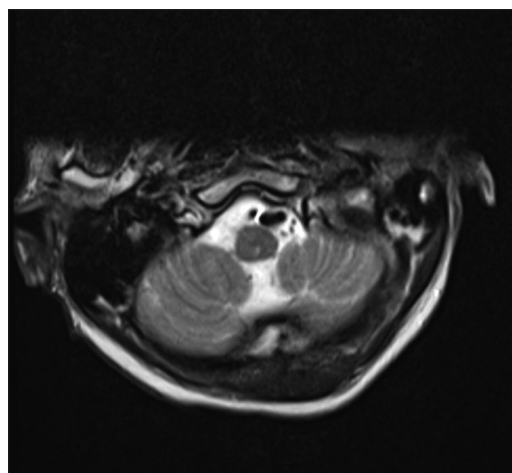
Axial magnetic resonance imaging sequences of the cervical spine demonstrating the odontoid screw lying within the ventral cervicomedullary junction.
